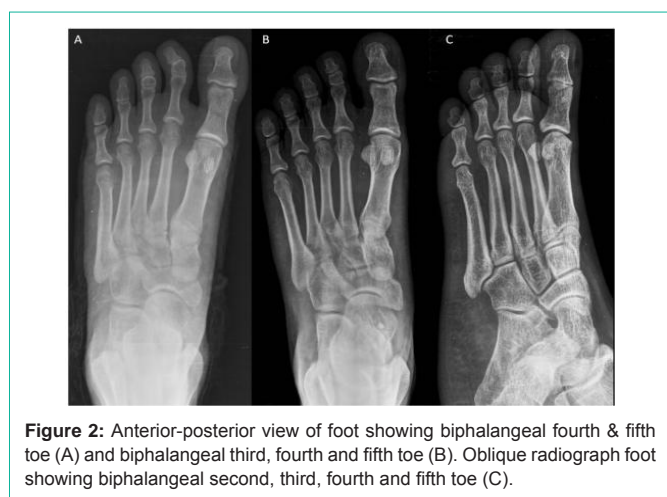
Anterior-posterior view of foot showing biphalangeal fourth & fifth toe (A) and biphalangeal third, fourth and fifth toe (B). Oblique radiograph foot showing biphalangeal second, third, fourth and fifth toe (C).
